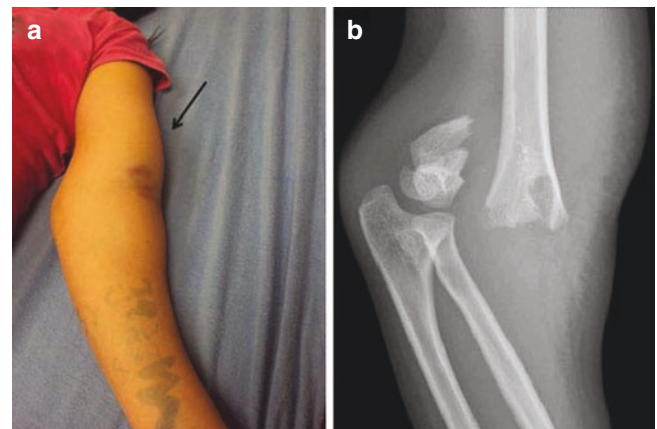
Bruising of the anterior elbow with displacement of the fracture in a 7-year-old girl who fell and has obvious deformity of the left elbow. Cubital fossa shows bruising (a) (arrow). Radiograph (b) shows type III supracondylar fracture of the humerus with marked displacement of the fracture ends. The proximal fragment had “buttoned through” the brachialis muscle, causing this bruising
